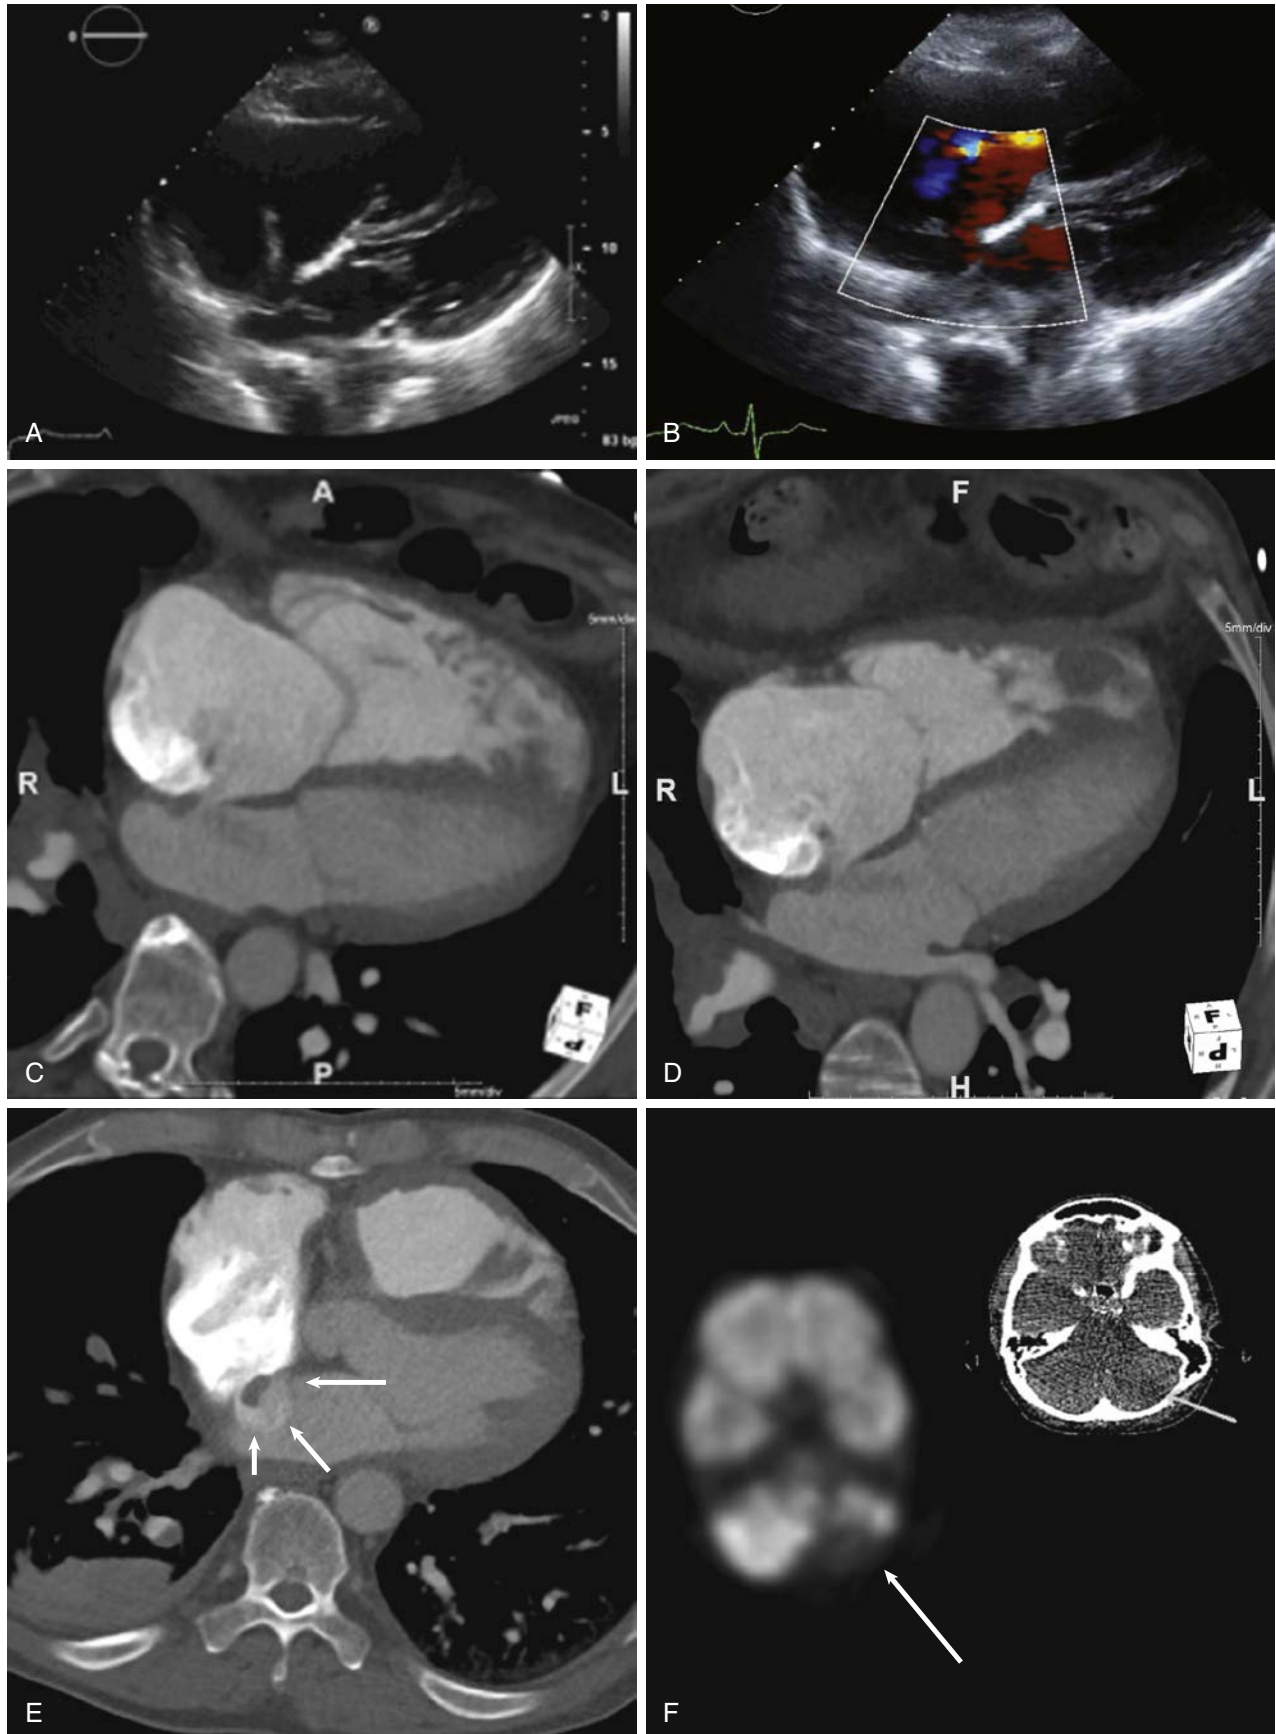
e6 (A) A 57-year-old man presenting with increasing shortness of breath and stabbing chest pain, as well as a history of deep vein thrombosis. A resting two-dimensional echocardiogram demonstrates a thin stalk-like structure originating from the interatrial septum into the right atrium. The differential diagnosis includes right atrial myxoma, thrombus, and malignant tumor and/or metastasis. (B) Two-dimensional Doppler demonstrating a flow from the left to the right atrium, suggesting a patent foramen ovale (PFO). (C) Corresponding four-chamber long-axis view in a contrast-enhanced computed tomographic angiogram demonstrating the gap in the interatrial septum with a contrast jet from the left into the right atrium. (D) A different angle demonstrates an additional mass in the right ventricular apex. (E) Atrial thrombus prolapses through the PFO, which shows the thrombus in transit. (F) Positron emission tomography (*left*) and magnetic resonance imaging (*right*) demonstrating cerebellar and right parietal infarcts consistent with a stroke based on paradoxical embolus.
